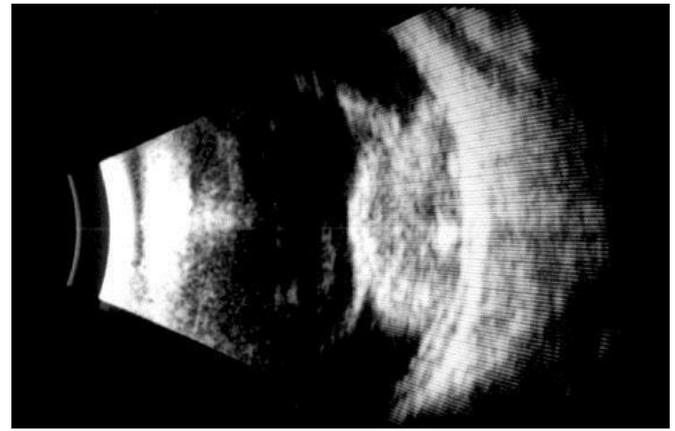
B Scan ultrasonogram showing a dome shaped mass lesion with low to medium internal reflectivity.
